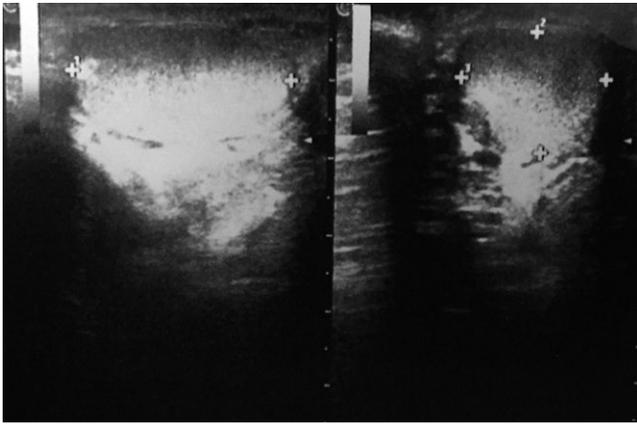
Scrotal ultrasound image of right testis revealing an inhomogeneous echogenicity
